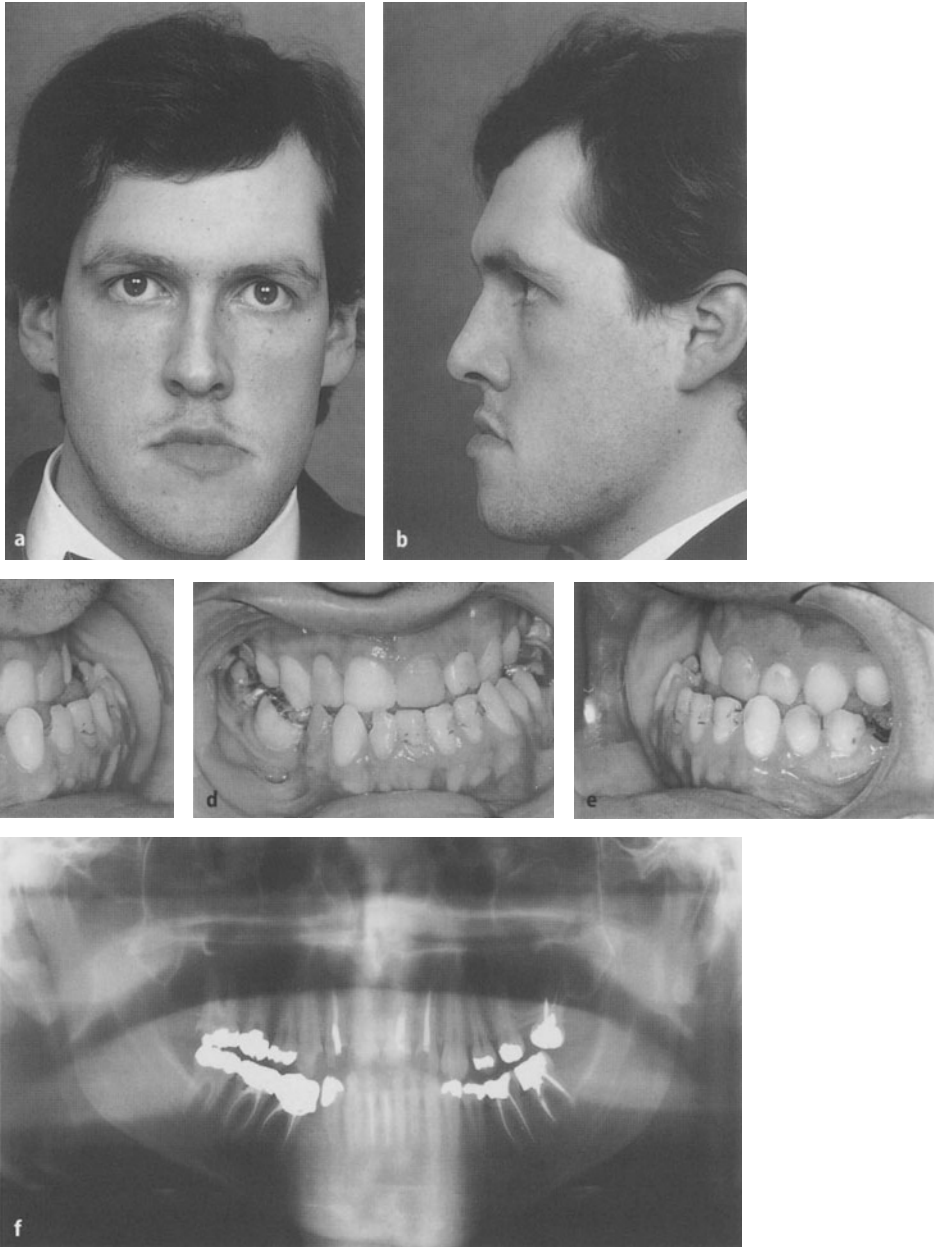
Bilateral, asymmetrical, questionable hybrid form with relapse after surgery. a, b Front and profile appearances of the patient resembling an acromegaly, but with severe chin deviation. c-e The patient's occlusion with deviation of the midline to the left by the width of a lower incisor. f In the panoramic radiograph the mandible looks strong and almost symmetrical with large condyles and thick necks, the right one a little elongated. The angles seem rather stretched
